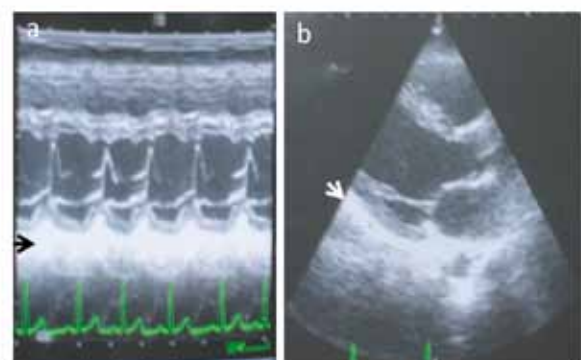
M-mode (a) and 2D (b) echocardiographs done 8 months after diagnosis showing highly echogenic and thickened pericardium (arrows) as complication of the recurrent lupus pericarditis.
